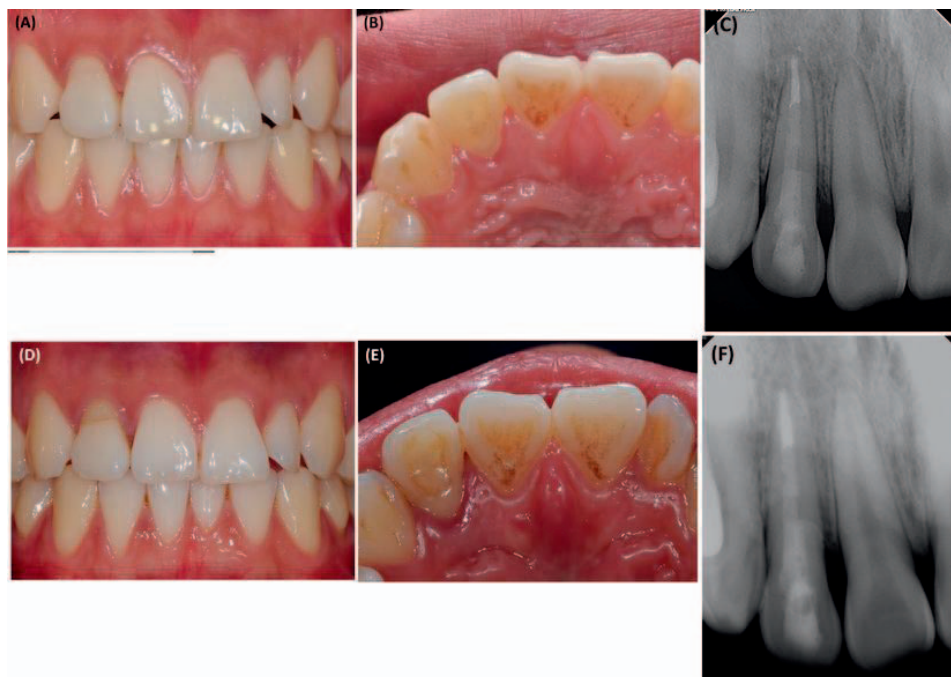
(A, B) Four-month follow-up photographs and (C) intraoral radiograph. (D, E) Five-year follow-up photographs and (F) intraoral radiograph.
